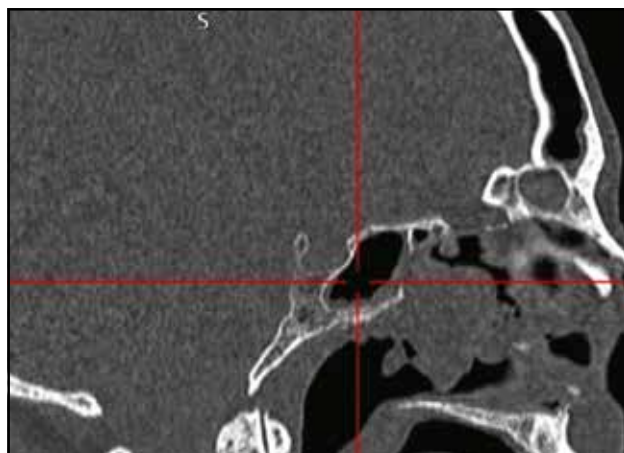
Incomplete sellar type pneumatization of the sphenoid sinus (cranio-facial CT scan, sagittal slice).
